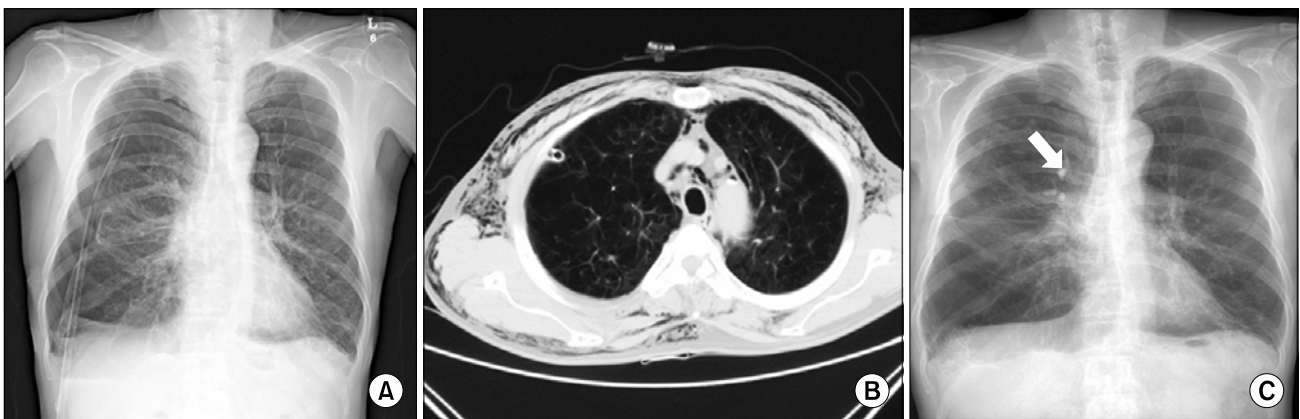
(A) A right pneumothorax was seen on admission chest X-ray. (B) Chest computed tomography revealed diffuse emphysema in both lungs. (C) The right pneumothorax was successfully treated, but the emphysema in the right lower lungs remained on chest X-ray after endobronchial Watanabe spigot (EWS) insertion. The arrow indicates the inserted EWS.
